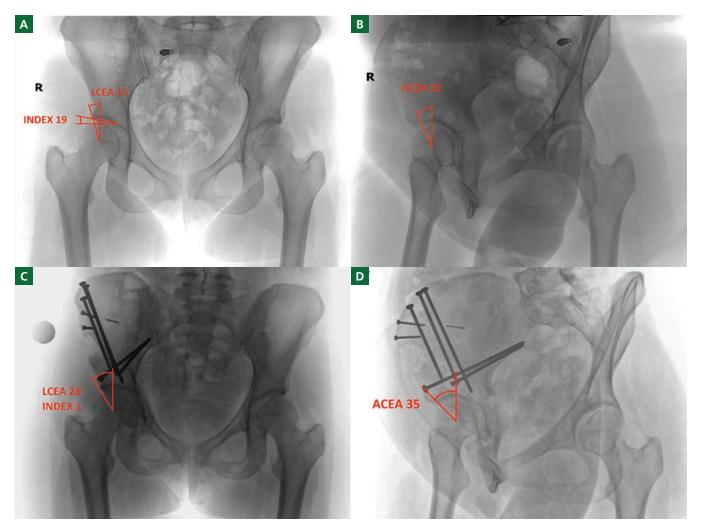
Pre- and Postoperative Radiographs of Pelvis in a 20-year-old Woman With Hip Dysplasia. Preoperative: A, anteroposterior with lateral center edge angle (LCEA) of 15° and acetabular index (INDEX) of 19° and B, false-profile with anterior center edge angle (ACEA) of 22°. Postoperative with improved parameters: C, anteroposterior with LCEA of 28° and index of 1° and D, false-profile with ACEA of 35°.
